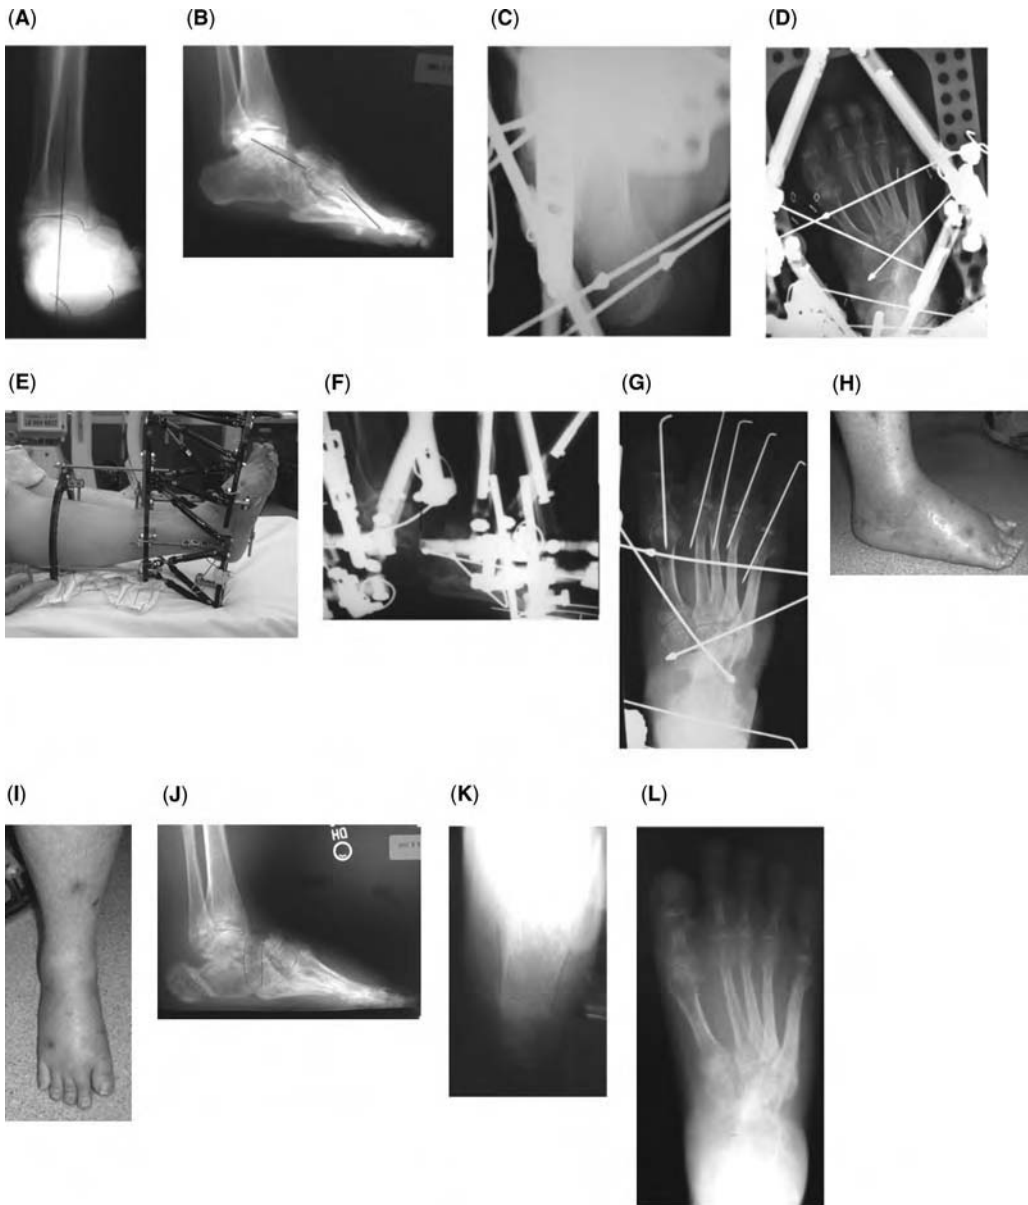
A 50-year-old woman with a cavus foot. She had a history of poliomyelitis and a triple arthrodesis malunion. Treatment included a calcaneal osteotomy to correct the heel varus and a midfoot osteotomy to correct the forefoot adduction and supination deformity. Distraction was done over a six-week period, after which the frame was converted to a holding frame for eight weeks followed by casting for four weeks. (A) Preoperative long axial radiograph shows varus malalignment of the calcaneal tuberosity relative to the tibial long axis. (B) Preoperative lateral radiograph of the foot shows plantarflexion of the first metatarsal relative to the talus. (C) Axial radiograph after calcaneal osteotomy and application of frame. (D) Anteroposterior (AP) foot radiograph after application of frame. Forefoot adduction is noted. (E) External fixator after application. (F) External fixator after distraction of midfoot osteotomy. (G) AP foot radiograph after correction of forefoot adduction, before frame removal. (H and I) Clinical improvement of cavus is noted after frame removal. (J-L) Lateral, axial heel, and AP radiographs after correction of deformity and healing of calcaneal and midfoot osteotomies.
